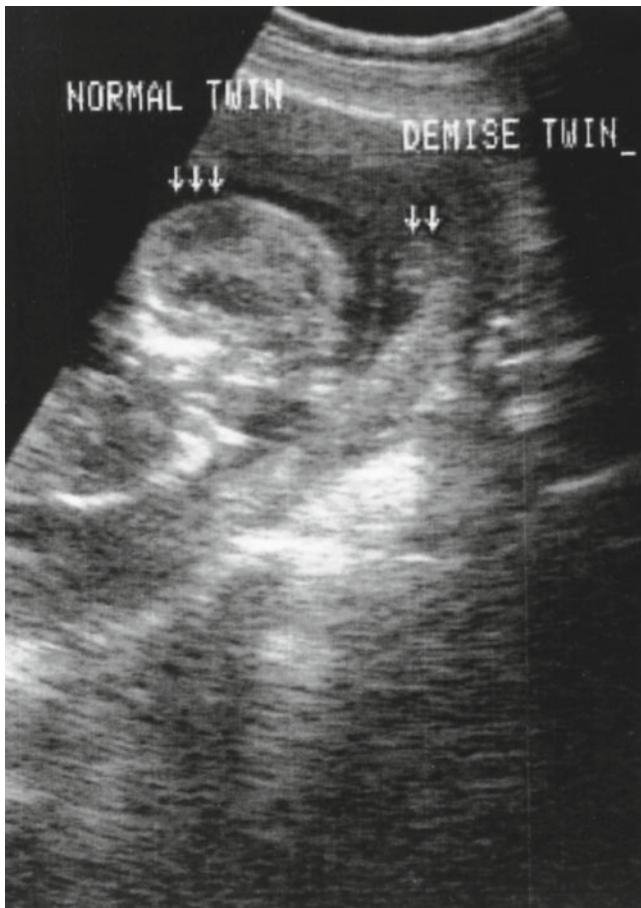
Sonogram at 14 weeks with one normal and one dead (“vanishing”) twin. The latter still has a separate cavity and measures 1.7 cm (Courtesy of Dr. J.D. Stephens, San Jose, California)
